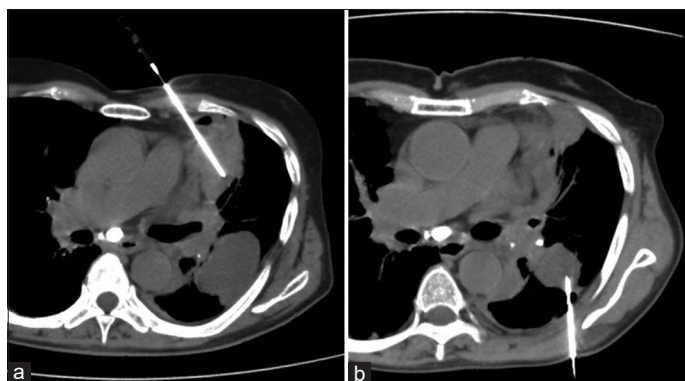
Axial computed tomography (CT) images showing aspiration of both the loculated fluid collections under CT guidance
